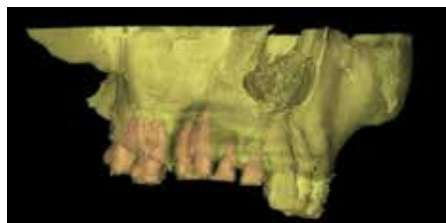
Reconstructed CT scan of the affected maxilla prior to restorative treatment planning.
